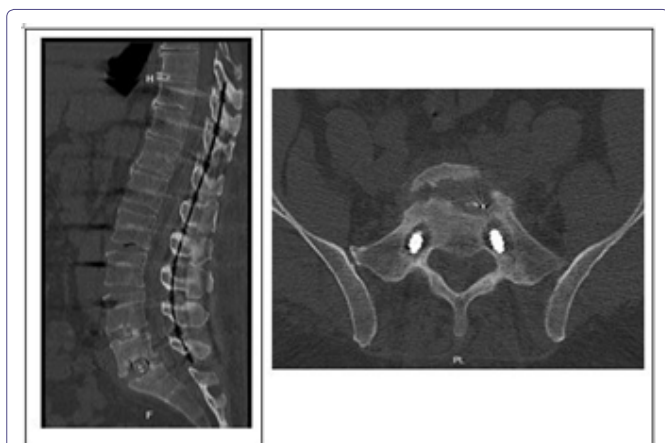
First Post-op CT: Intersomatic fusion mass without complete consolidation, sacroiliac joint vacuum in S1 instrumentation with left predominance.
